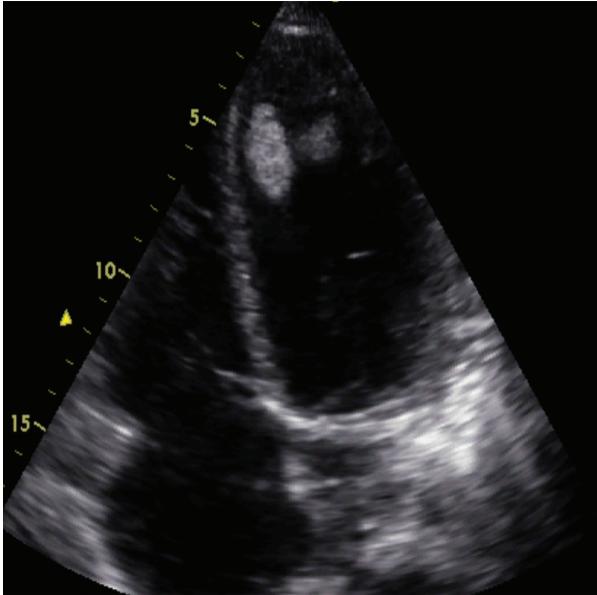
Echocardiography: apical four-chamber view with thrombus in the left ventricle
